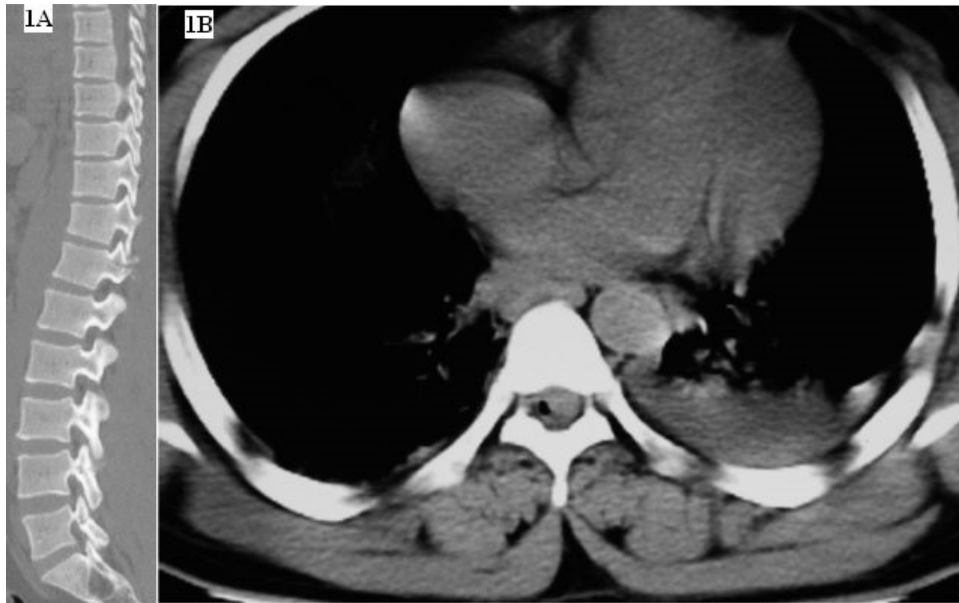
Sagittal spinal CT image revealing undisplaced fracture of parsinterarticularis and pedicle of D12 vertebra (1a) and axial chest CT scan showing intradural droplet of air at D12 vertebra level (1b)
